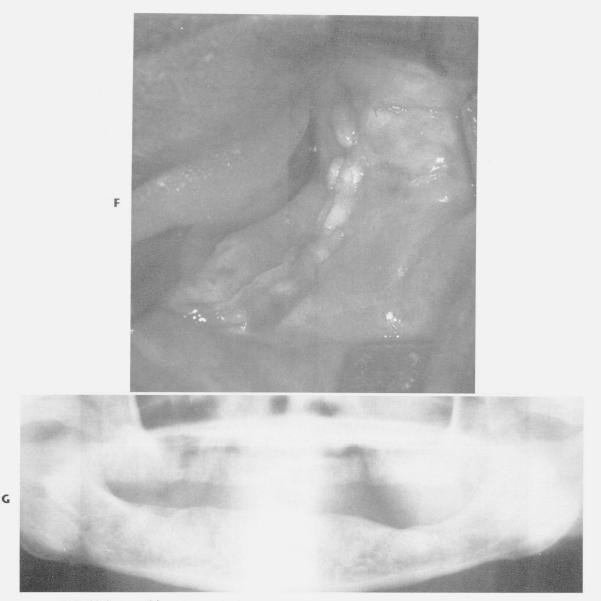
cont'd F, Closure of soft tissues. G, Panoramic radiograph 8 months after surgery showing slight remodeling and healing of the bone.
